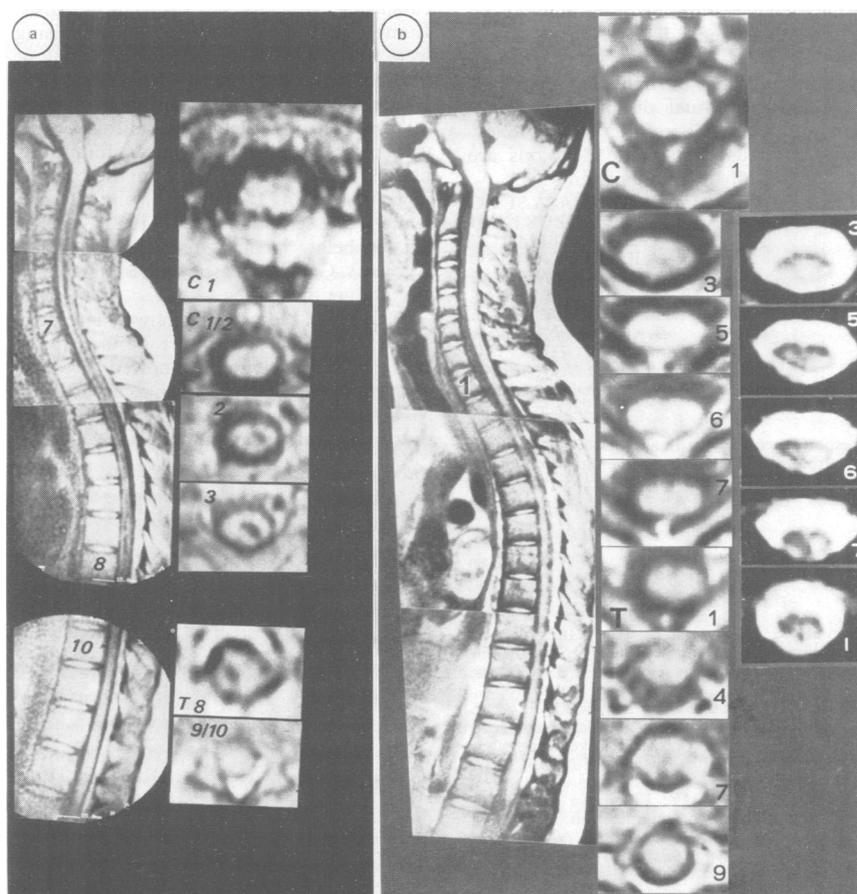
1st MRI of whole spinal cord (left: TR = 500 TE = 40 sagittal, right: TR = 500 TE = 30 axial image) showing a Chiari malformation and syrinx in the spinal cord.
